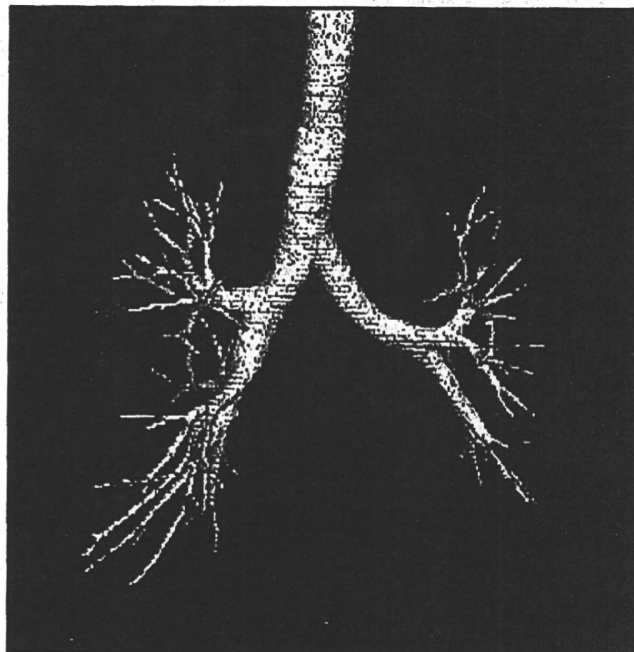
Three-dimensional image of bronchial tree made from high-resolution CT.
